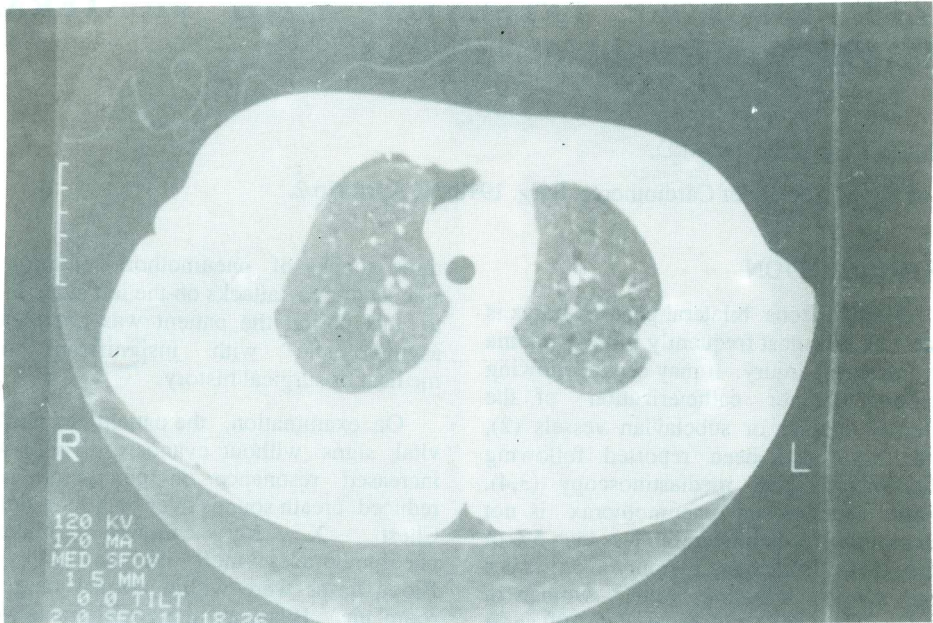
CT Scan of the chest, showing multiple small thin walled cysts distributed uniformly in both lungs with residual right anterior pneumothorax.
